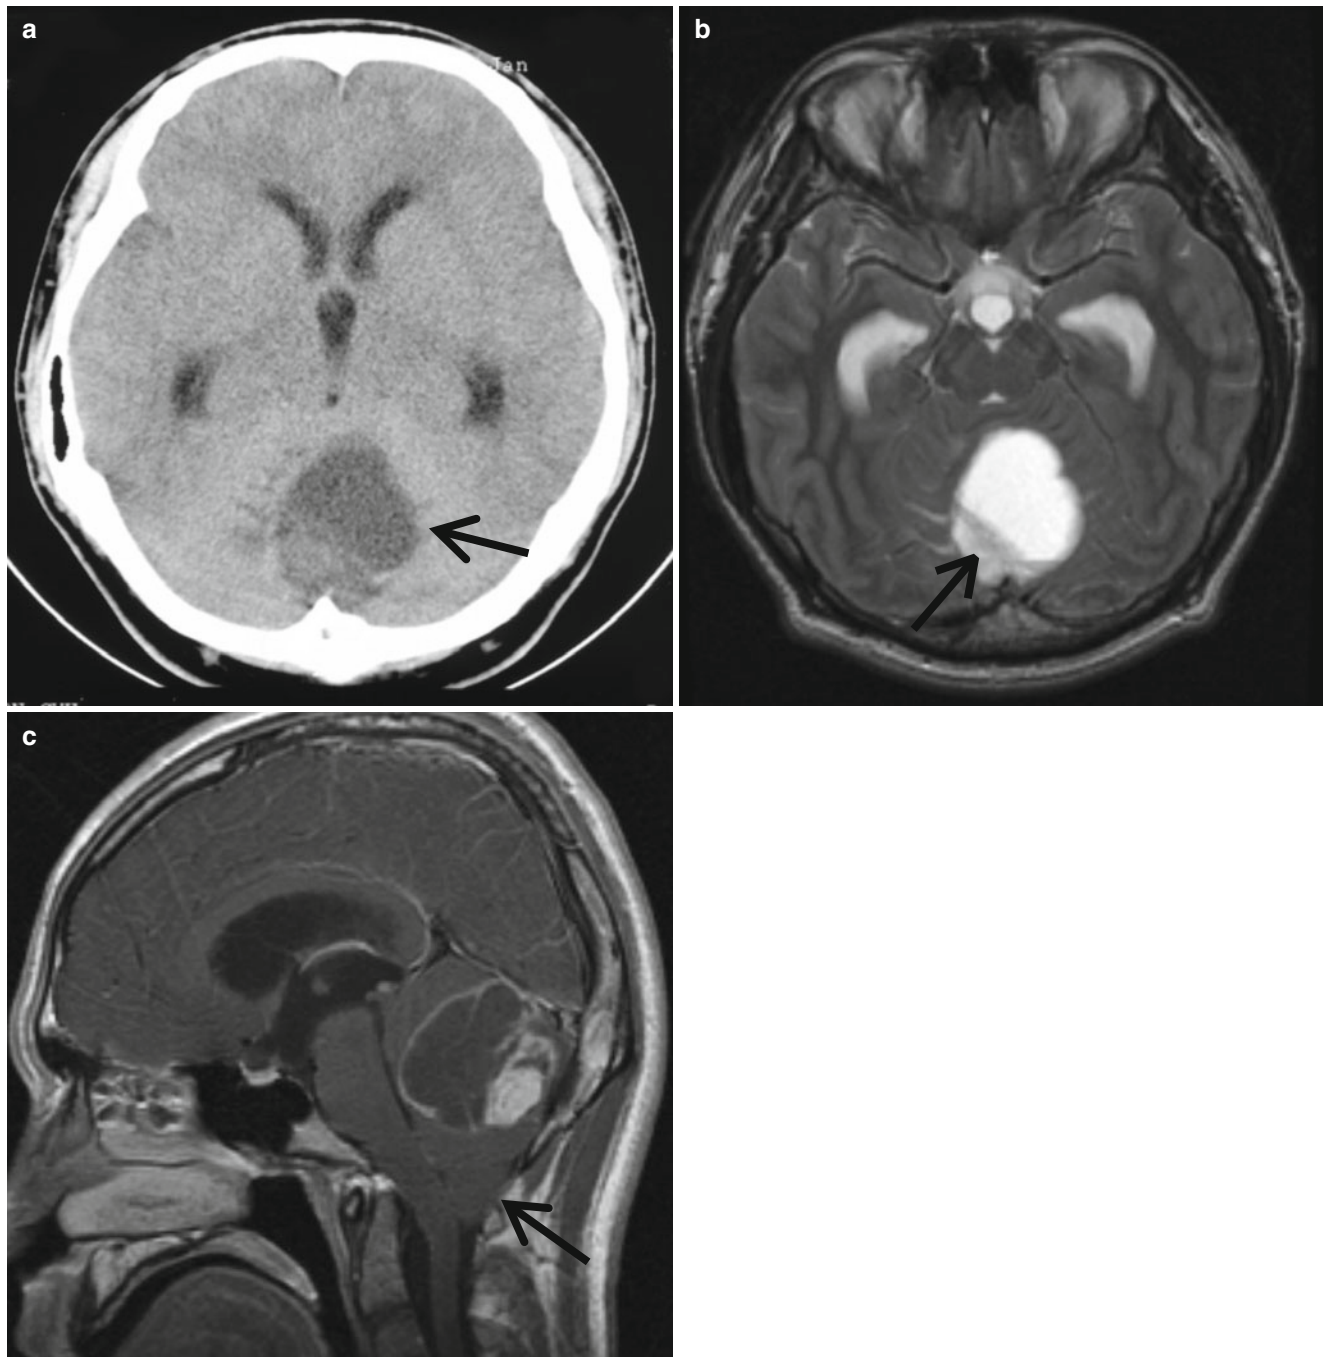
Cystic cerebellar JPA in an 18-year-old boy. (a) CT scan shows cystic mass with solid portion (*arrow*), which appears low attenuated compared to the normal parenchyma. (b) Solid portion exhibits high intensity on T2-weighted image (*arrow*). (c) Postcontrast sagittal
